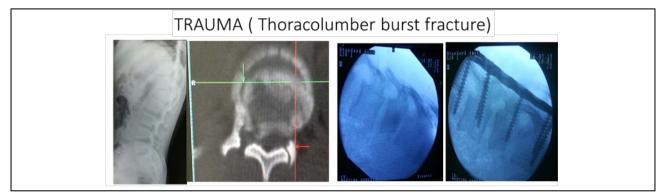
CT, intraoperative localisation and post operative images of thoracolumbar burst fracture.
